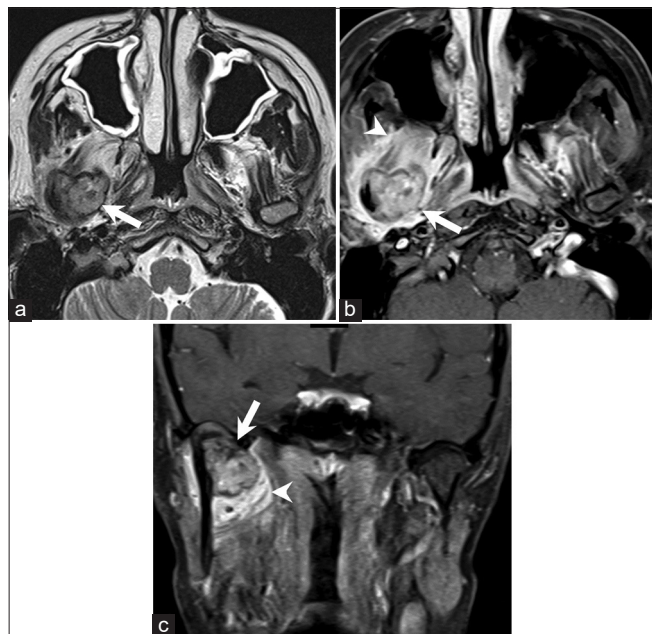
Chondroblastoma. A 36-year-old woman with chondroblastoma arising from the right mandibular condyle presenting with worsening right jaw pain. Axial T2WI MRI image (a), axial (b) and coronal (c) contrast-enhanced T1W MRI images with fat suppression show an exophytic enhancing T2 hyperintense mass arising from the right mandibular condyle projecting medially into the right masticator space (arrows). Note edema and enhancement of the right lateral pterygoid muscle (arrow heads).
